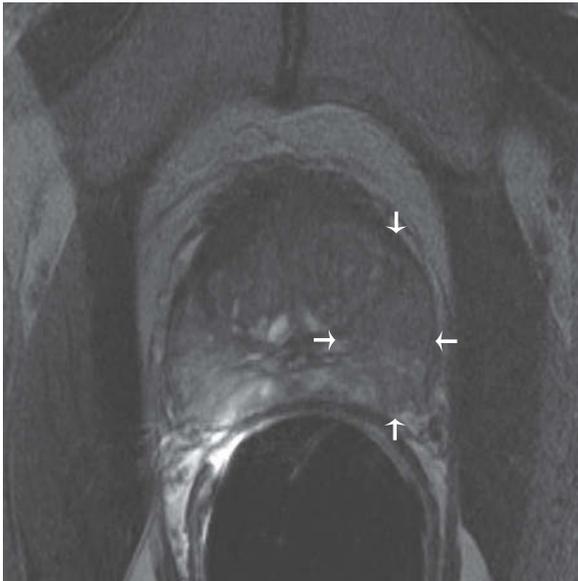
Extracapsular extension of prostate carcinoma in a 66-year-old male. Axial T2-weighted image at the level of the midgland demonstrates diffuse low signal intensity tumor with extension into the left periprostatic fat (arrows).
